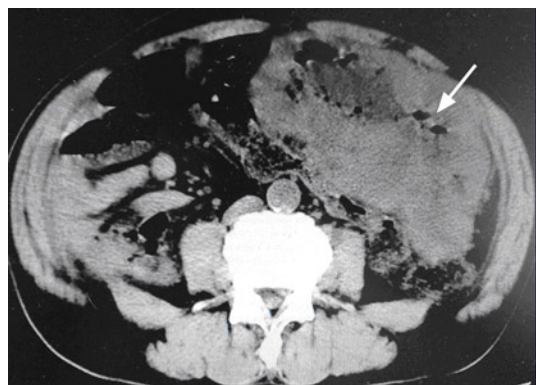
The abdominal CT scan showed a heterogenous mass (arrow) with zone of parenchymal necrosis occupying most part of the left abdominal cavity
